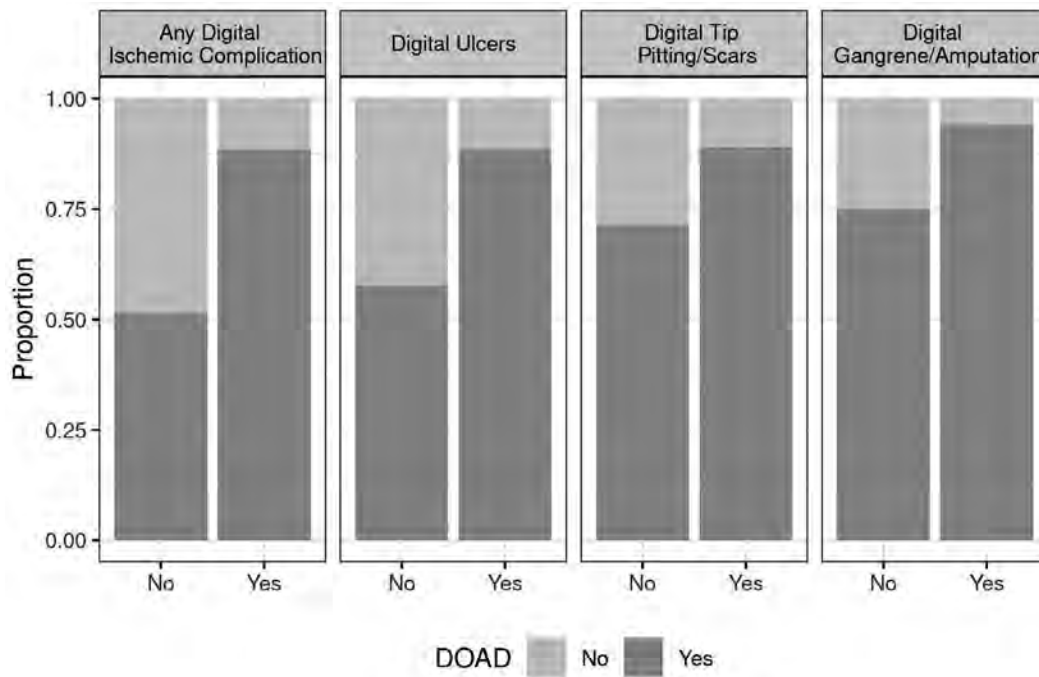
Correlation between Presence of Digital Occlusive Arterial Disease (DOAD) on Laser Doppler Flowmetry and Digital Ischemic Complications in Systemic Sclerosis
